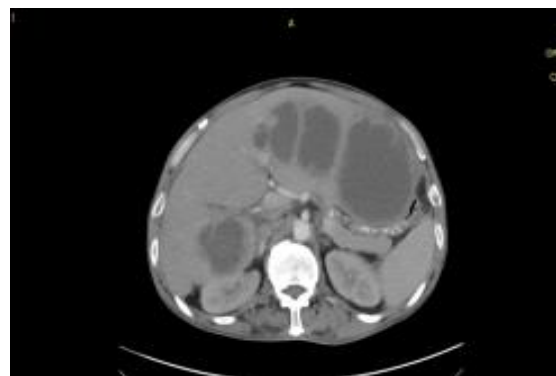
Corresponding CT showing multiple well defined hypodense lesion with enhancing walls and few septae.
